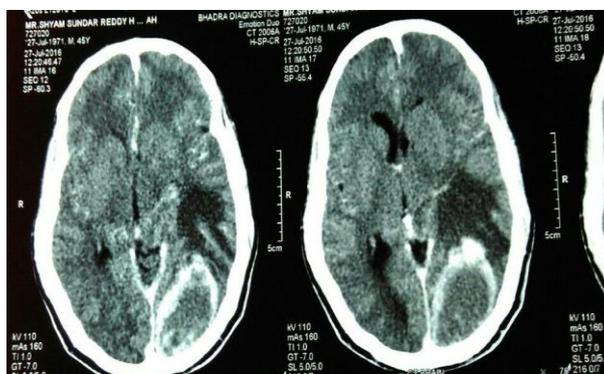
CT scan brain showing metastases
